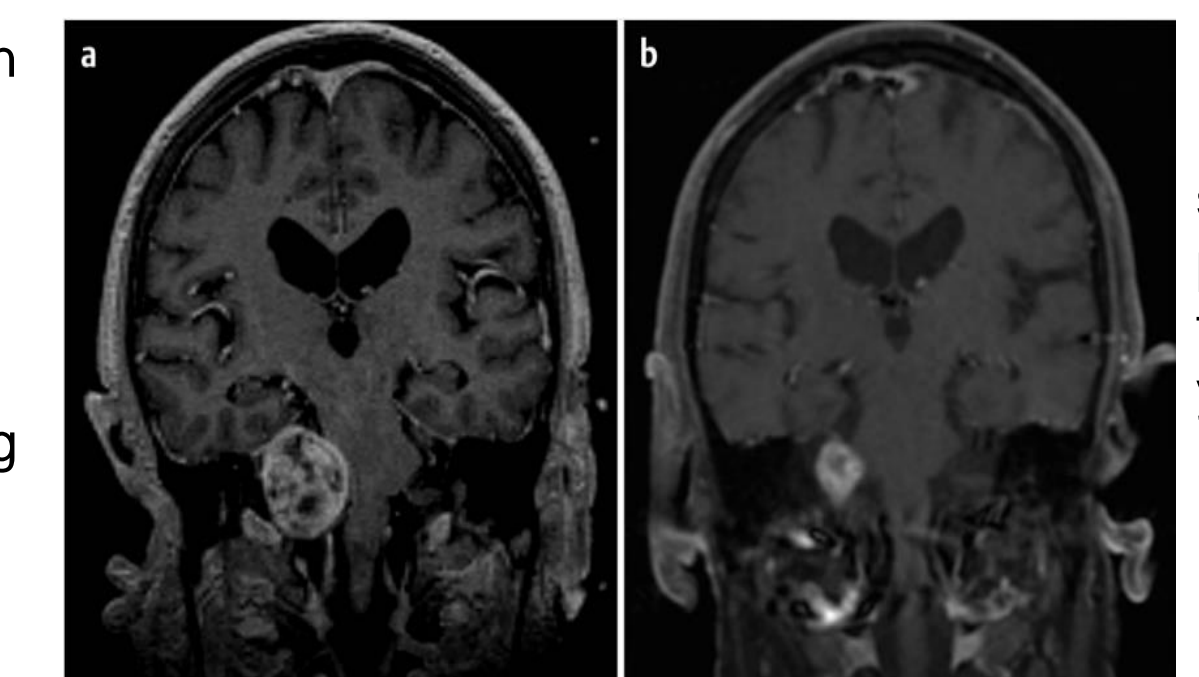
is an MRI of the same patient post treatment following up 4 years later
